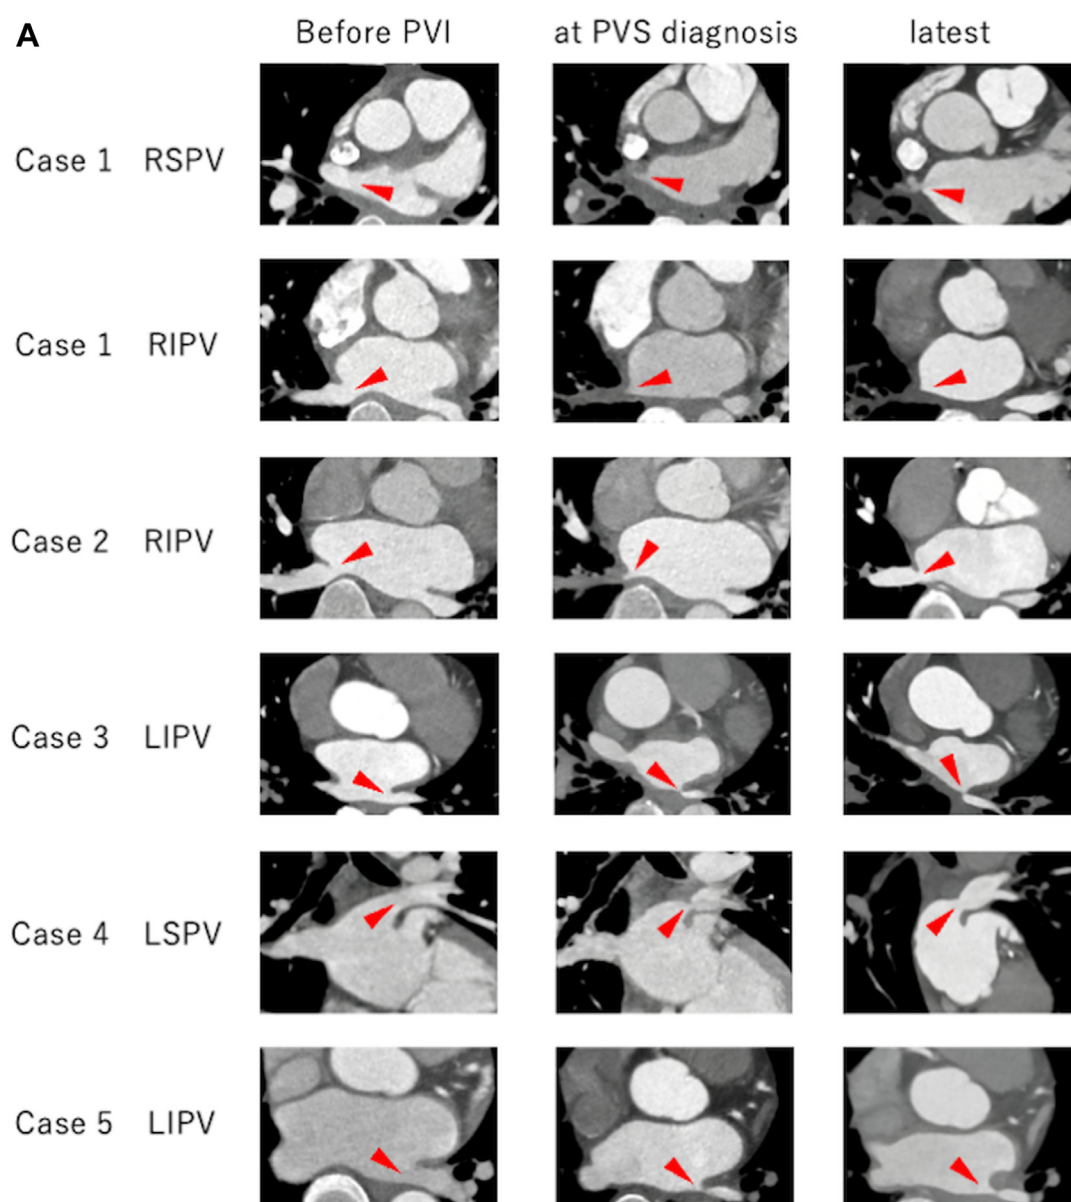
A: Computed tomography image showing the pulmonary vein. The *left, middle, and right columns* show contrast-enhanced computed tomography images before pulmonary vein isolation at the time of diagnosis of pulmonary vein stenosis (PVS) and at final follow-up, respectively. The *red arrows* indicate the PVS sites. B: Pulmonary angiography of the representative case (case 4, second balloon angioplasty). The *left, middle, and right columns* show pulmonary angiography during the procedure of balloon angioplasty before, during, and post balloon dilation, respectively. The *red arrows* indicate the PVS sites. LIPV = left inferior pulmonary vein; LSPV = left superior pulmonary vein; RIPV = right inferior pulmonary vein; RSPV = right superior pulmonary vein.
